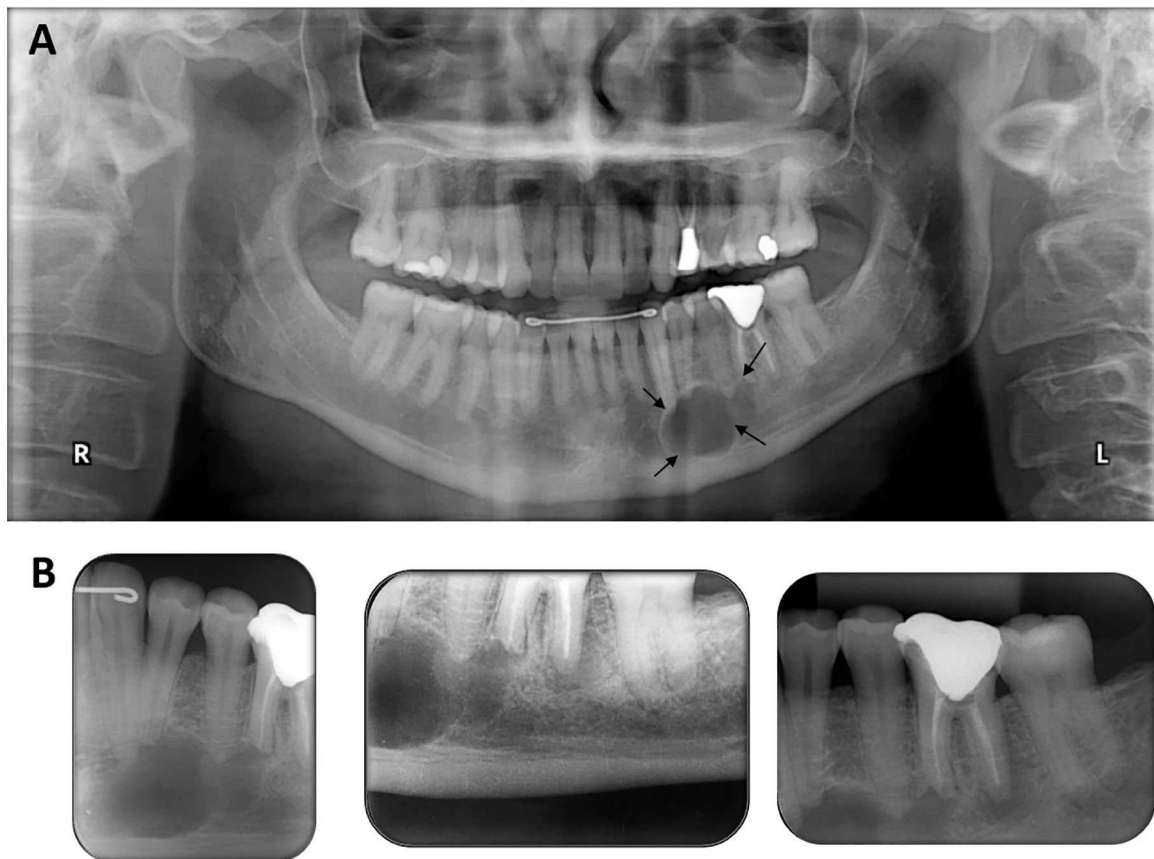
(A) Panoramic x-ray showing the bilocular radiolucent lesion in the apical region of the teeth 33, 34, 35 and 36 (arrows). (B) Periapical radiographs showing more details of the lesion. There was no root resorption and displacement of other involved teeth.
